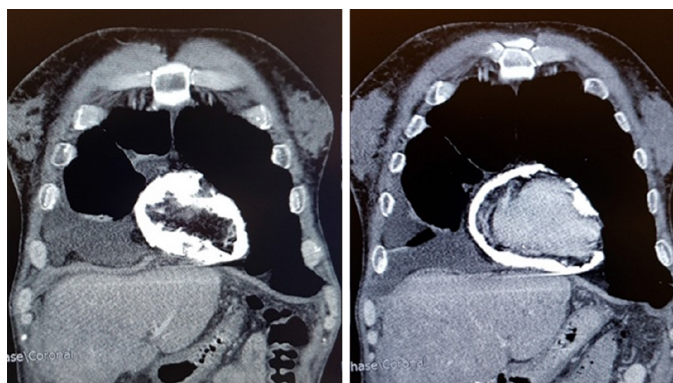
Computed tomography of the heart with excessive pericardial calcifications.
